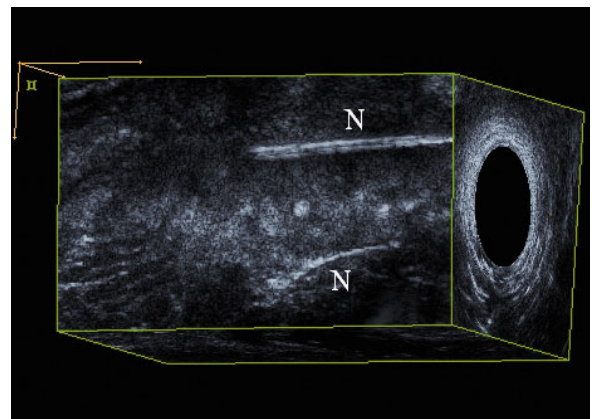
Ultrasound needle (*N*) localization of muscles. Sagittal view of two needles inserted into the iliococcygeus muscle. Image obtained by 2050 transducer (B-K Medical)
